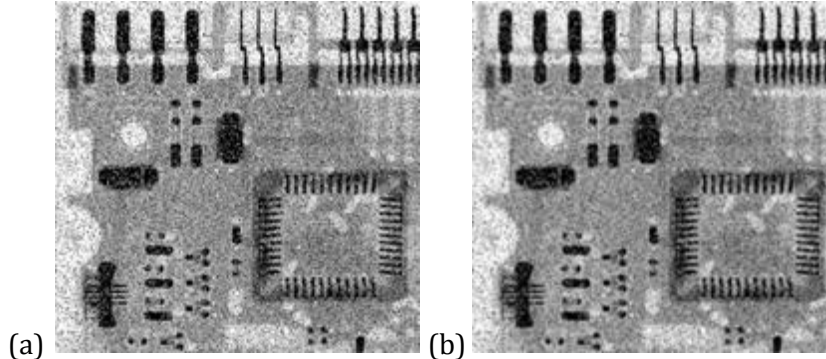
Noise reduction of (a) X-ray image of circuit board corrupted by salt-and-pepper noise, using a 3 x 3 averaging mask, resulting in image (b) [206].
